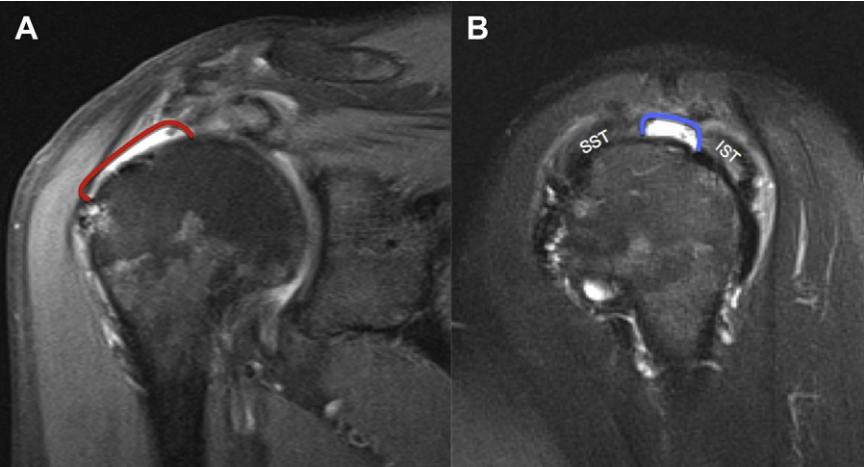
(A, B) U-shaped tear. A fluid-filled cuff defect is seen at the junction of the supraspinatus and infraspinatus tendons on coronal (A) and sagittal (B) oblique fat-suppressed T2-weighted images of the right shoulder. The U-shape is defined by a long longitudinal component (*red line*) compared with a narrow transverse component (*blue line*), and is typically found at the junctional zone of the supraspinatus and infraspinatus tendons.
